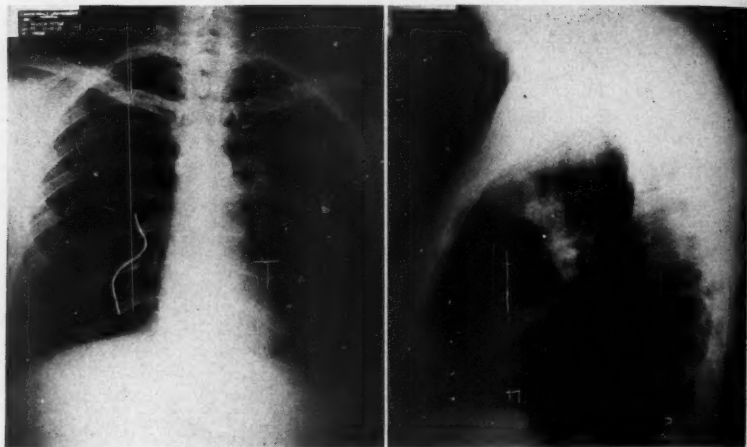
Case 7. Roentgenograms which show a dense mass in the hilar region of the left lung.
